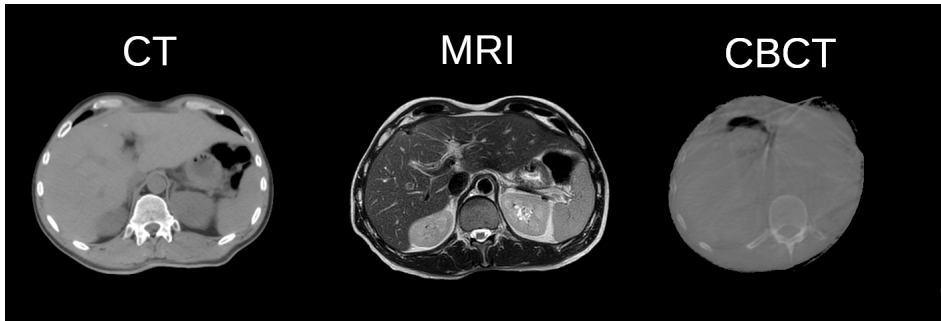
Examples of images used in radiotherapy. Anatomical imaging of the liver of the same patient using different imaging modalities in the transversal orientation. On the left is a CBCT, in the middle is a CT, and on the right is a T_2 -weighted MRI. The CBCT images are used for position verification before treatment, while the CT and MR images are also used to identify tumors and plan treatment. The CBCT has a limited field of view and limited image contrast. The CT has a larger field of view but limited image contrast. The MRI shows superior soft-tissue contrast and clear visualization of the organs and small structures.
